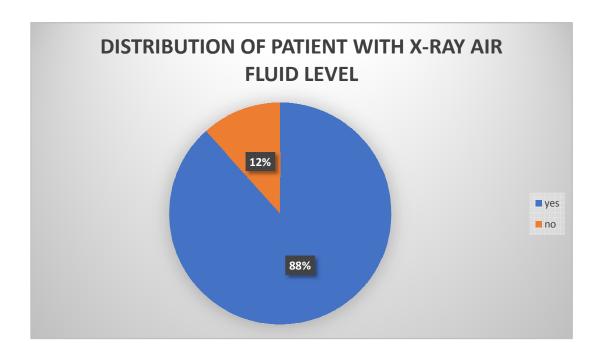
Distribution of X-ray air fluid level
